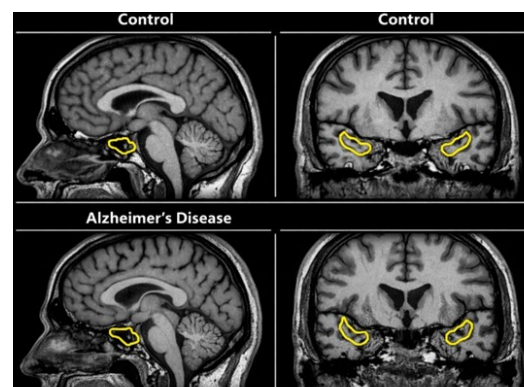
Representative T1-weighted 3T MRI images demonstrating hippocampal atrophy in Alzheimer disease (AD) patient compared to age-matched control. Sagittal and coronal T1-weighted images demonstrate reduced hippocampal volume and medial temporal lobe atrophy in AD. Images were acquired using Siemens Magnetom Prisma 3T MRI (Germany).
